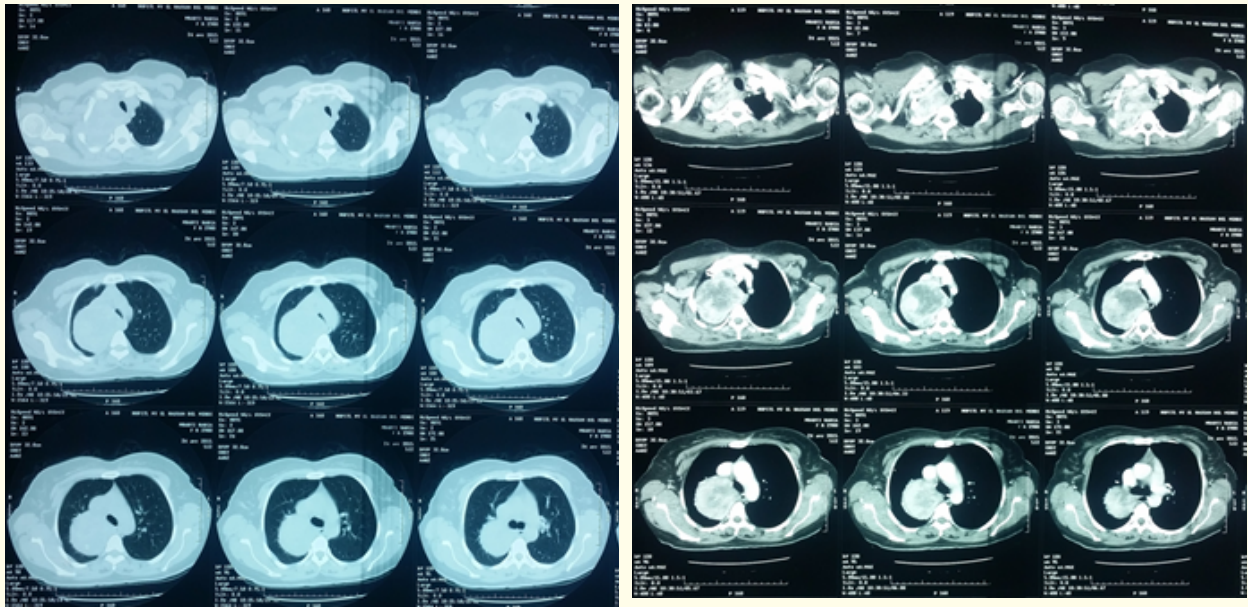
The CT-scans objectified a tissular process in right upper lobe.
